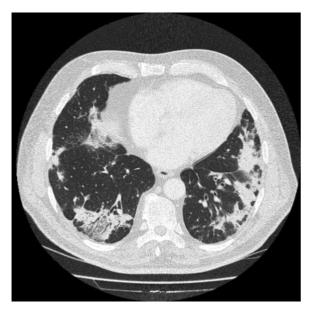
Chest imaging in a patient with cryptogenic organizing pneumonia (typical migrating pattern). (A) Chest radiograph and (B) chest computed tomographic (CT) scan at initial presentation showing alveolar peripheral opacities predominating in the left lung. (C) Chest radiograph and (D) chest CT 2 months later showing contralateral opacities. (E) Chest radiograph 6 months after initial presentation showing alveolar opacities in the upper lobes.
